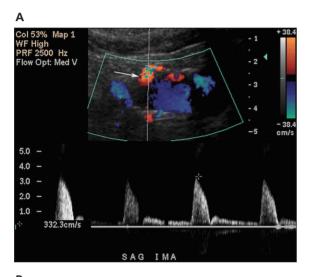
Color and pulsed Doppler image of a normal IMA showing a characteristic high-resistance waveform pattern.
